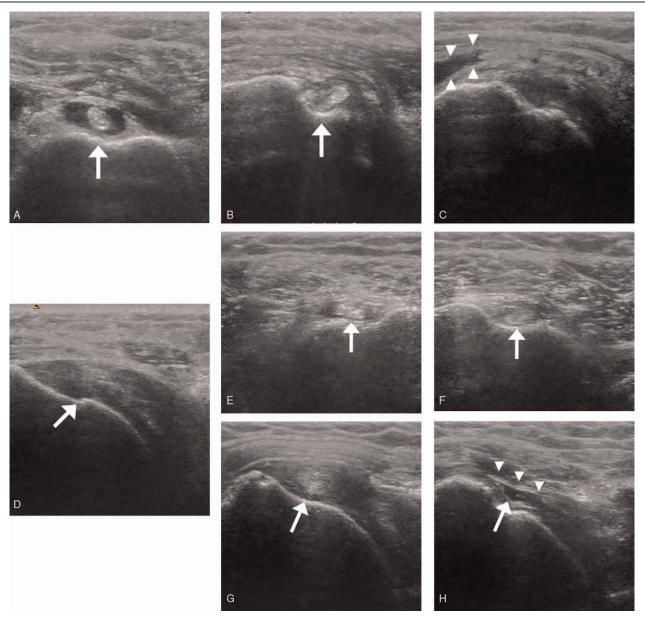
Ultrasonographic findings of the bilateral shoulder joints in the acute phase of dislocation (A) (left biceps tendon, transverse view), (B) (right biceps tendon, transverse view): the echogenicity of the bilateral biceps long tendons are heterogeneous, and fluid accumulation is observed in the tendon sheath (arrow), particularly on the left side. (C) (left supraspinatus tendon, longitudinal view): fluid accumulation between the supraspinatus tendon and deltoid muscle (arrowheads). (D) (right supraspinatus tendon, longitudinal view): the echogenicity of the right supraspinatus tendon is heterogeneous (arrow). The ultrasonography findings of the bilateral biceps tendon, transverse view), (F) (right biceps tendon, transverse view): the echogenicity of the right supraspinatus tendon, transverse view): the echogenicity of the bilateral biceps tendon, transverse view), (G) (left supraspinatus tendon, longitudinal view): the echogenicity of the tendon sheath (arrow). (G) (left supraspinatus tendon, longitudinal view): the echogeneous. (H) (right supraspinatus tendon, longitudinal view): an anechoic lesion (arrow) in the right supraspinatus tendon, longitudinal view): an anechoic lesion (arrow) in the right supraspinatus tendon and deltoid muscle herniation (arrowheads) are shown in the sonogram and are compatible with a complete tear of the right supraspinatus tendon.
